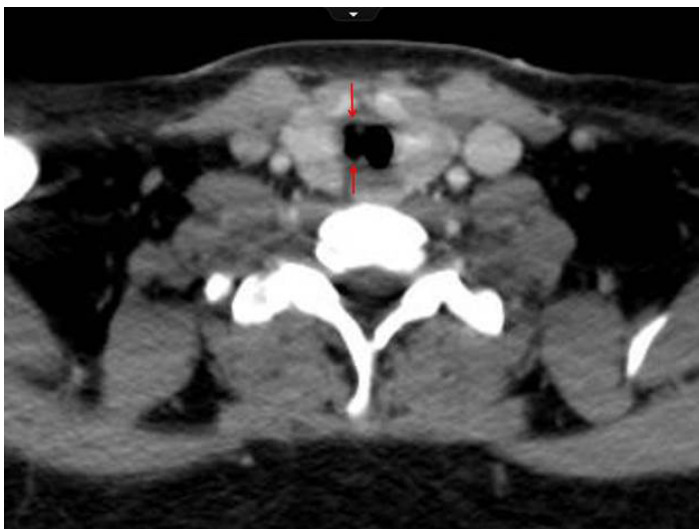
CT scan of the chest. Arrows indicate the attachment of the tracheal web to the tracheal wall.
